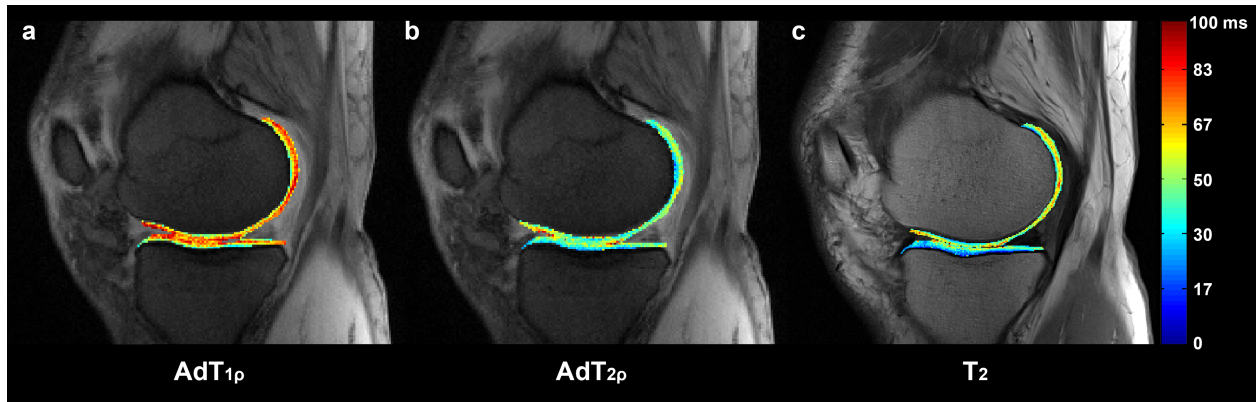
Different regional distributions of adiabatic $T_{1\rho}$ (a) and $T_{2\rho}$ (b) and standard T_2 (c) across tibiofemoral cartilage of a representative subject (65 years, male). The three quantitative MRI parameters can provide complementary information regarding structural abnormalities.
